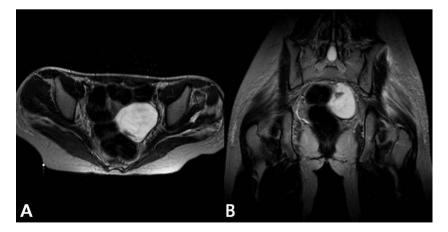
Axial T1 weighted MRI (A) and coronal T2-weighted MRI (B): a multilocular mass is present superior to the uterus, inseparable from the left ovary. The mass has a dominant lobulated portion that contains a heterogeneous internal component.
